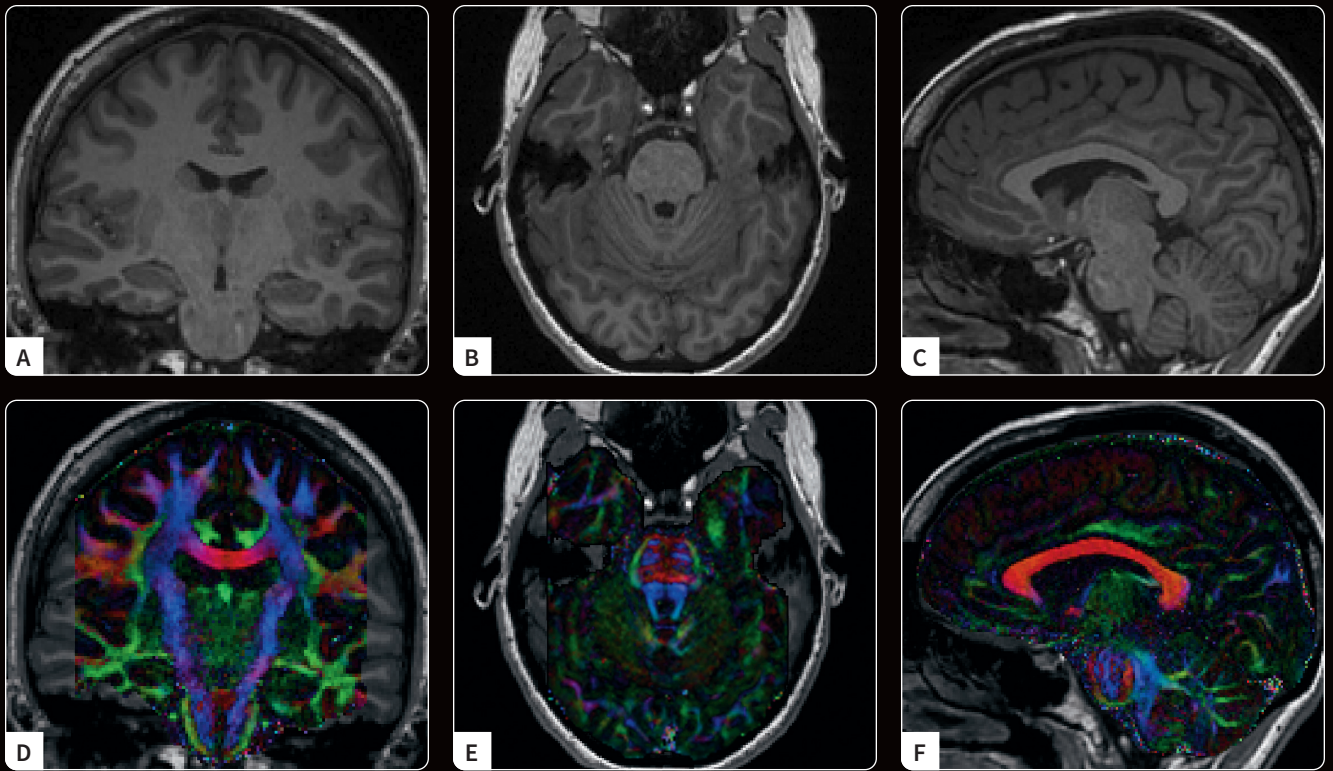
A 1 mm isotropic DWI with $b_{max}=2000 \text{ s/mm}^2$ collected in approximately 11 min. Shown are (A-C) 3D T1w images and (D-F) DWI color orientation maps overlaid on the T1w. Image credit: Jose Guerrero-Gonzalez, MS, Waisman Center.
